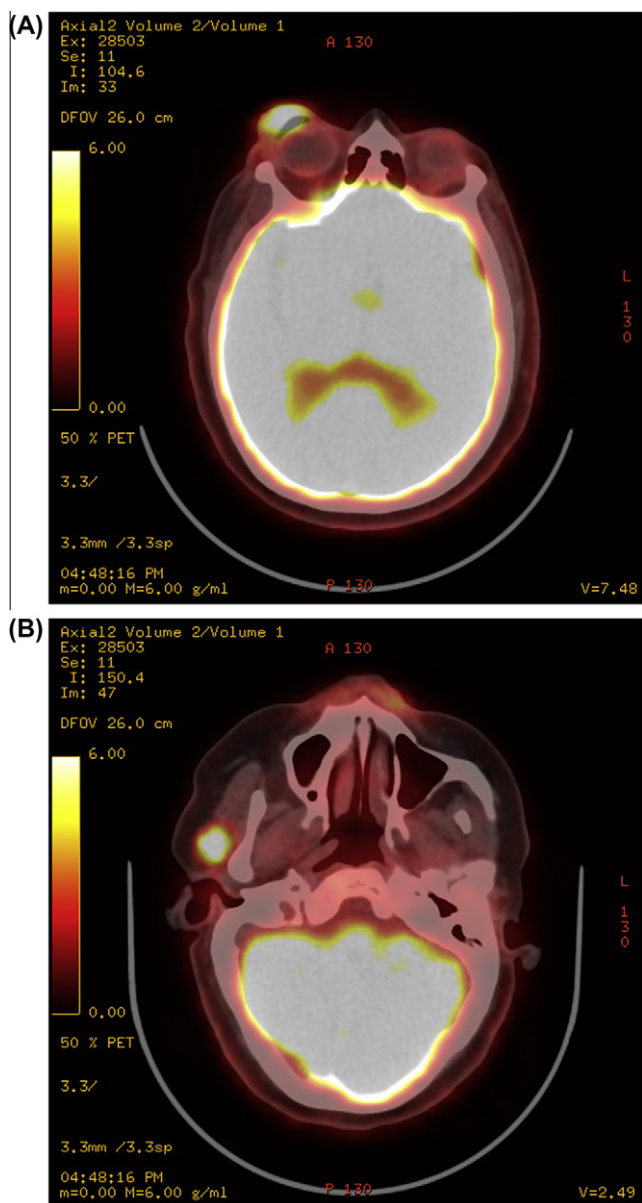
PET/CT findings in a patient with Merkel cell carcinoma of the eyelid. (A) FDG uptake in the upper eyelid. (B) FDG uptake in the parotid nodal basin. The patient also had a palpable mass in the parotid. PET/CT was ordered to rule out other sites of distant metastasis.
